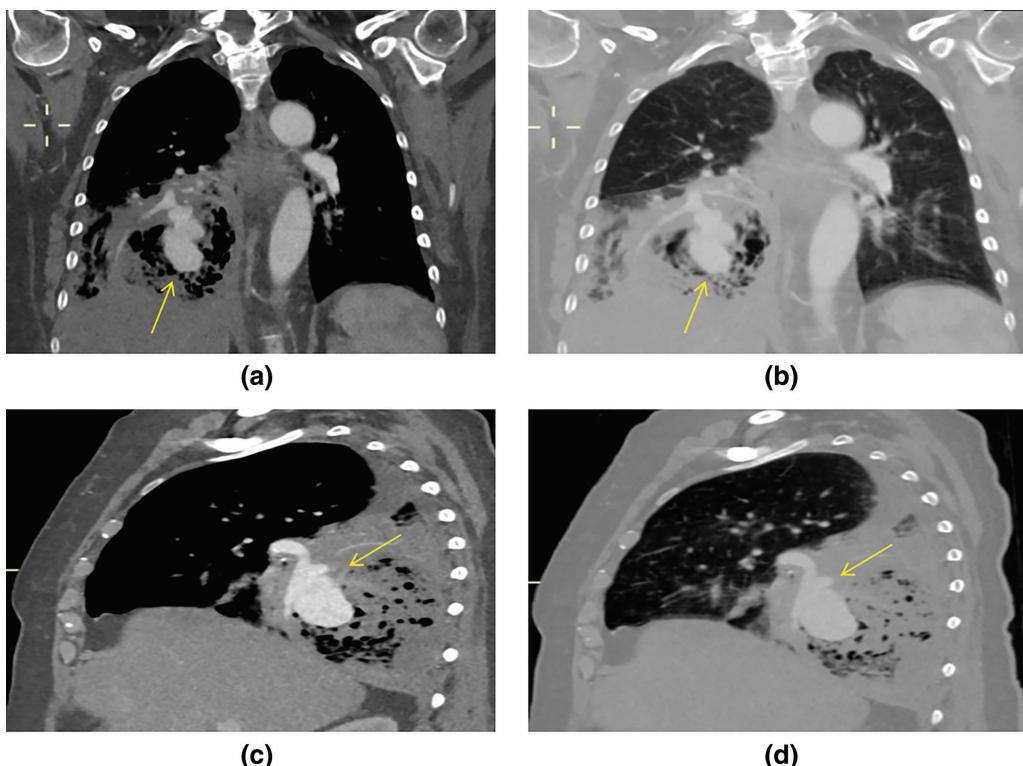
CT scan. CT scan showing in coronal (a,b) and sagittal (c,d) reconstructions showing the lower right pulmonary lobe almost completely replaced by colliquated metastases with evidence of a giant pseudoaneurysms (yellow arrows) of the posterior lower branch of the right pulmonary artery.
